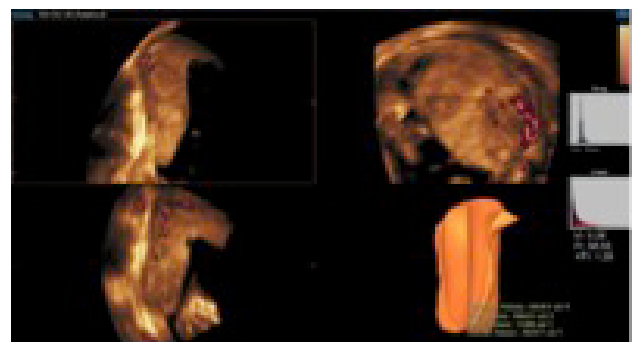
3D power Doppler with histogram showing vascular indices of the placenta.
